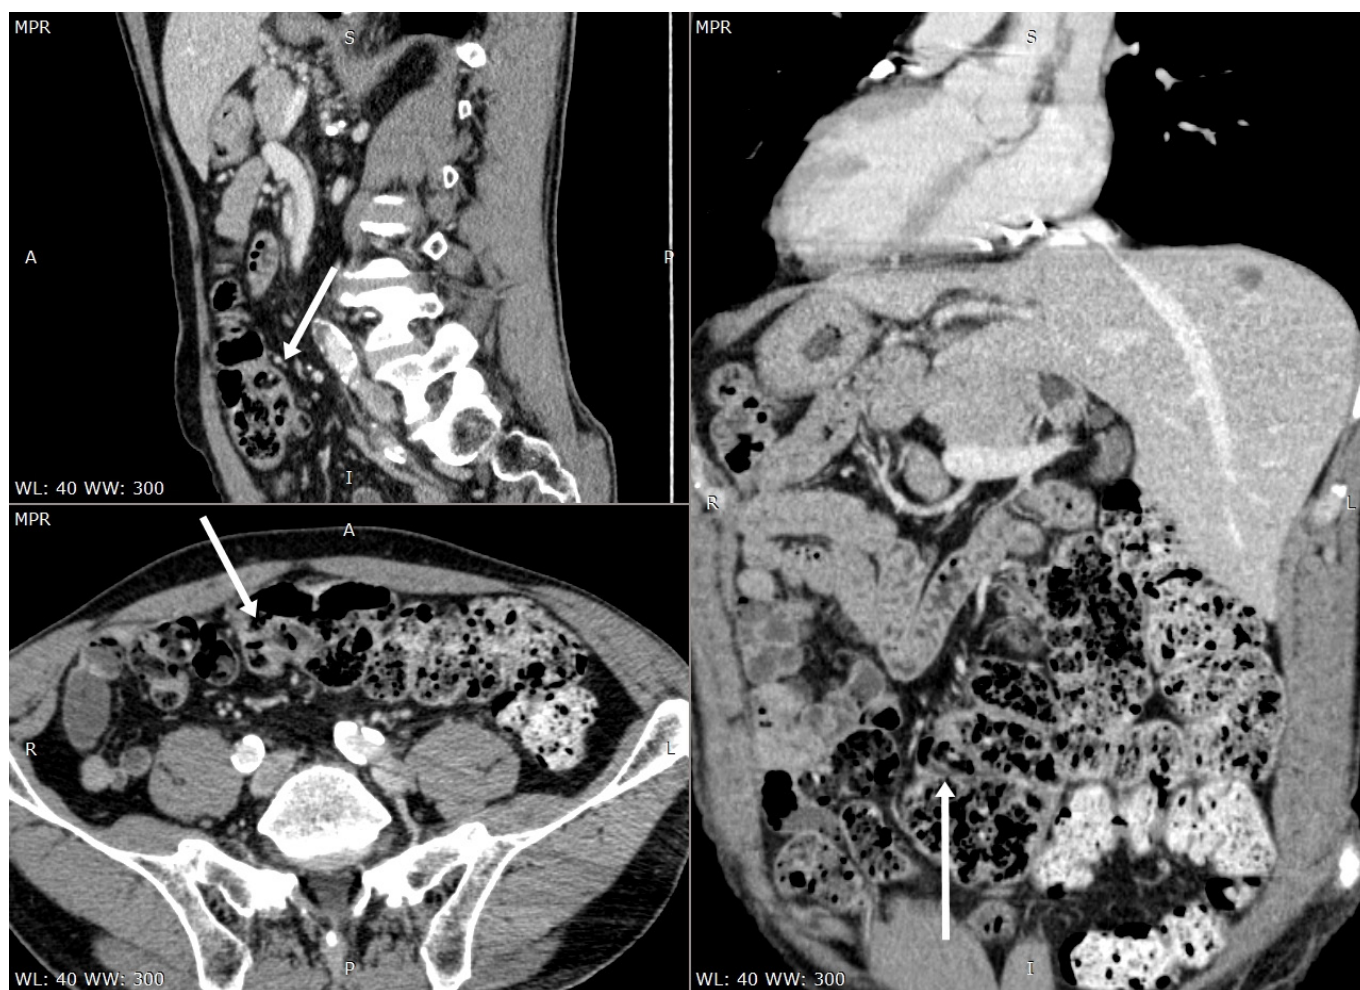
CT scan image – contrast enhanced MPR portal venous phase; white arrows indicate ileocecal junction(upper image sagittal view, lower image axial view, right image coronal view)
